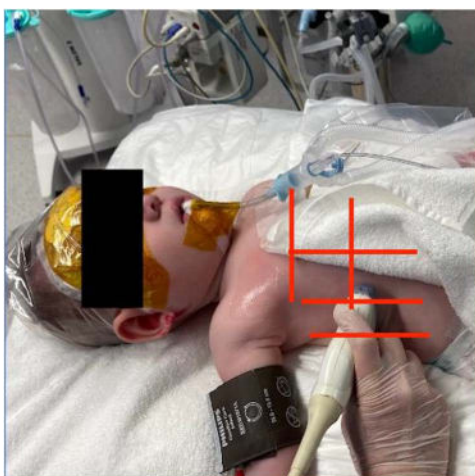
An ultrasound examination of the lateral lung field with a linear probe oriented transversely (figure courtesy of Serpil Ozgen).
